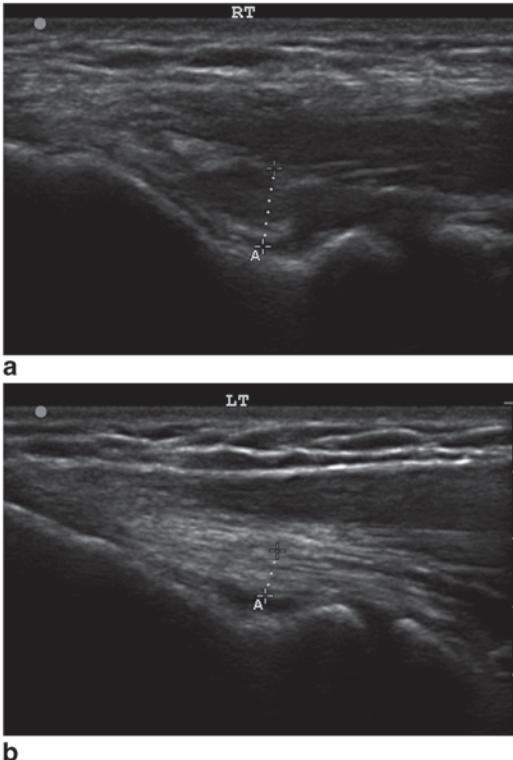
Longitudinal ultrasound view of a a hypoechoic signal (cursors) in the anterior band (A) of the UCL of a pitcher and b compared to the normal anterior band (A') of the contralateral ligament (cursors)
